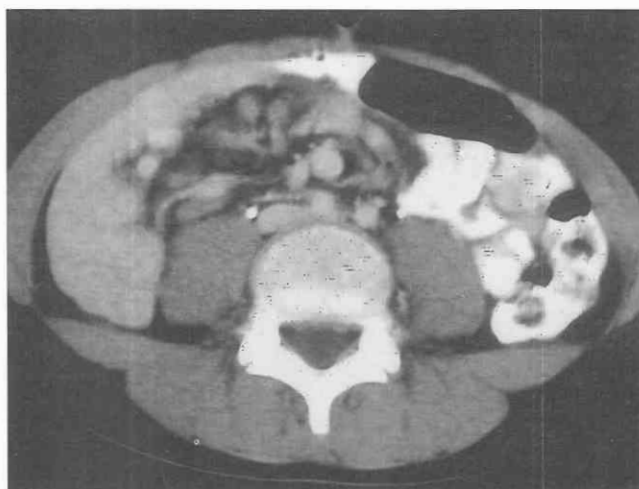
Midgut malrotation. CT scan through the midabdomen in a patient with midgut malrotation demonstrates inversion of the superior mesenteric vessels, with the superior mesenteric vein positioned to the left of the superior mesenteric artery.
